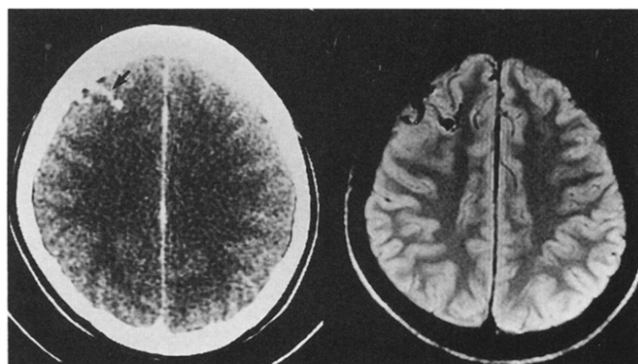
Case 1: Contrast-enhanced CT scan (left), demonstrating a "vermiform" enhancement in the right frontal lobe (arrow), which corresponds to a flow-void image on proton density-weighted MRI (TR 2000; TE 30) (right). These findings are consistent with the presence of a vascular malformation.
